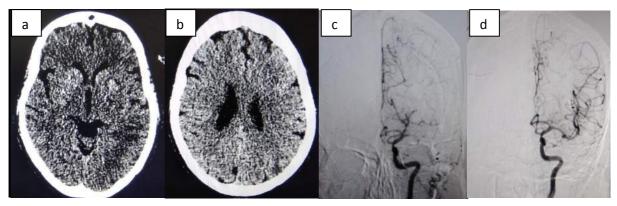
65 year old female patient, diabetic and hypertensive, presented with right hemiparesis with an NIHSS of 15 within 2.5 hours after the stroke onset. Plain CT showed an ASPECTS of 6/10 (a, b) (lentiform, insula, M3, M2) with CT angiogram showing left MCA-M1 occlusion. DSA showed left MCA-M1 occlusion (c). She was taken up for endovascular therapy with recanalization of left MCA (d). She recovered and at discharge her NIHSS improved to 4.
